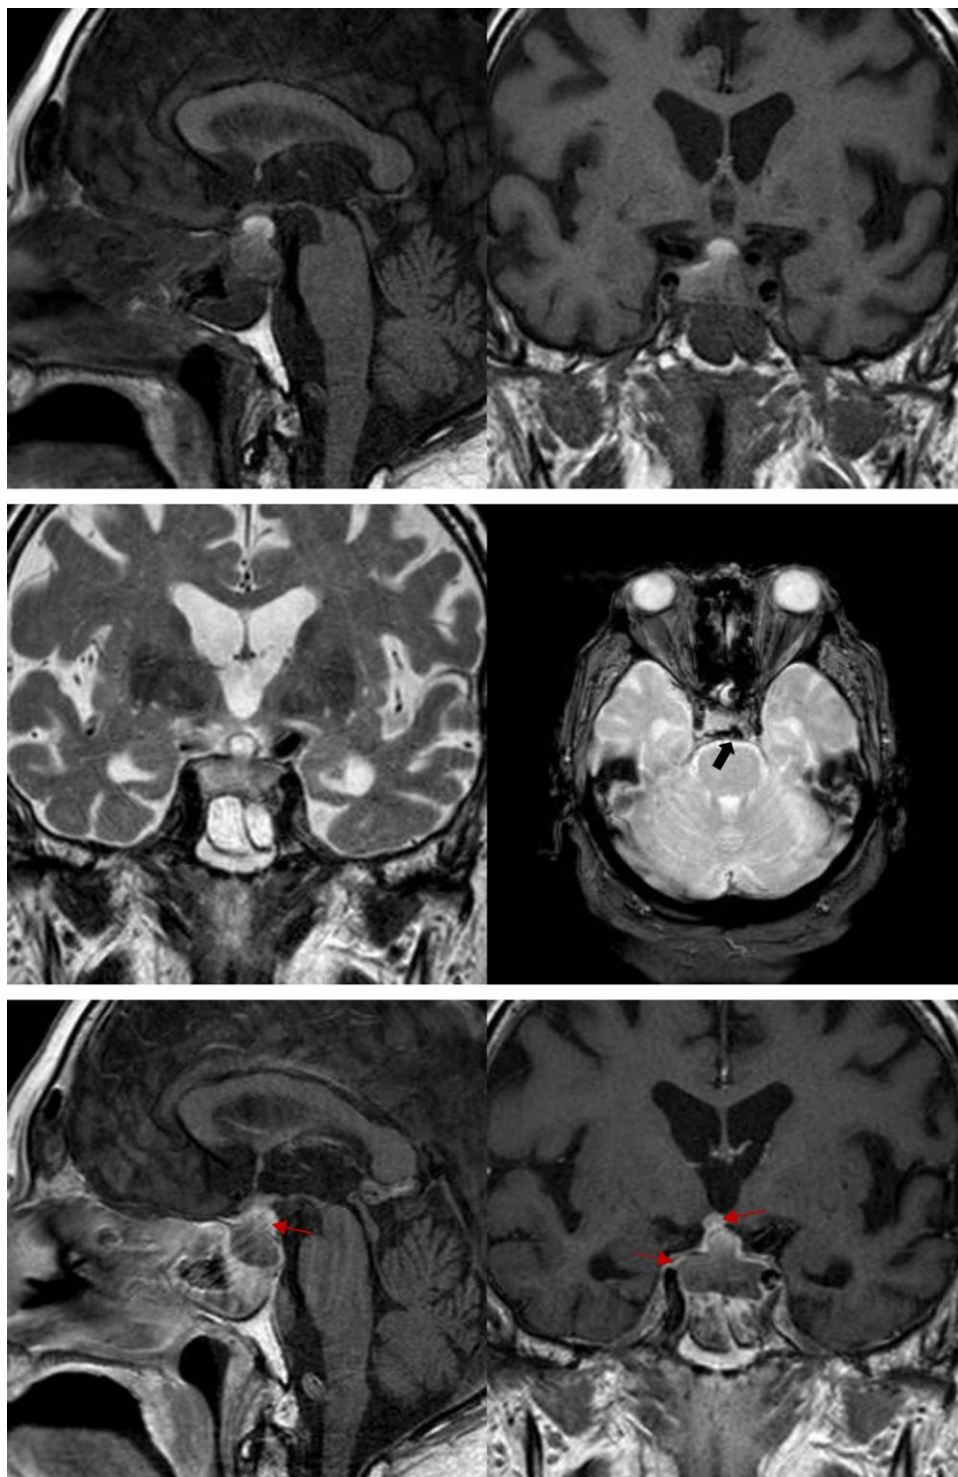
The first magnetic resonance imaging examination confirmed a sellar and suprasellar mass iso-hyperintense to the brain tissue on T1 and T2 weighted images with an hypointense area on T2*Fast Field Echo images as hemosiderin component (black arrow) in possible subacute bleeding. After intravenous injection of gadolinium, an evident ring sign, thickening of the pituitary stalk, and infundibulum and dural tail sign (red arrow) have been detected; an evident sphenoidal mucosal thickening is also present.
